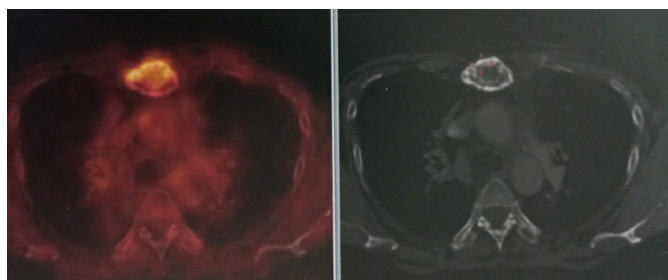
PET-CT (April 2017) showing FDG avid lytic sclerotic lesion involving the sternum (SUV_{max} 7.8).
